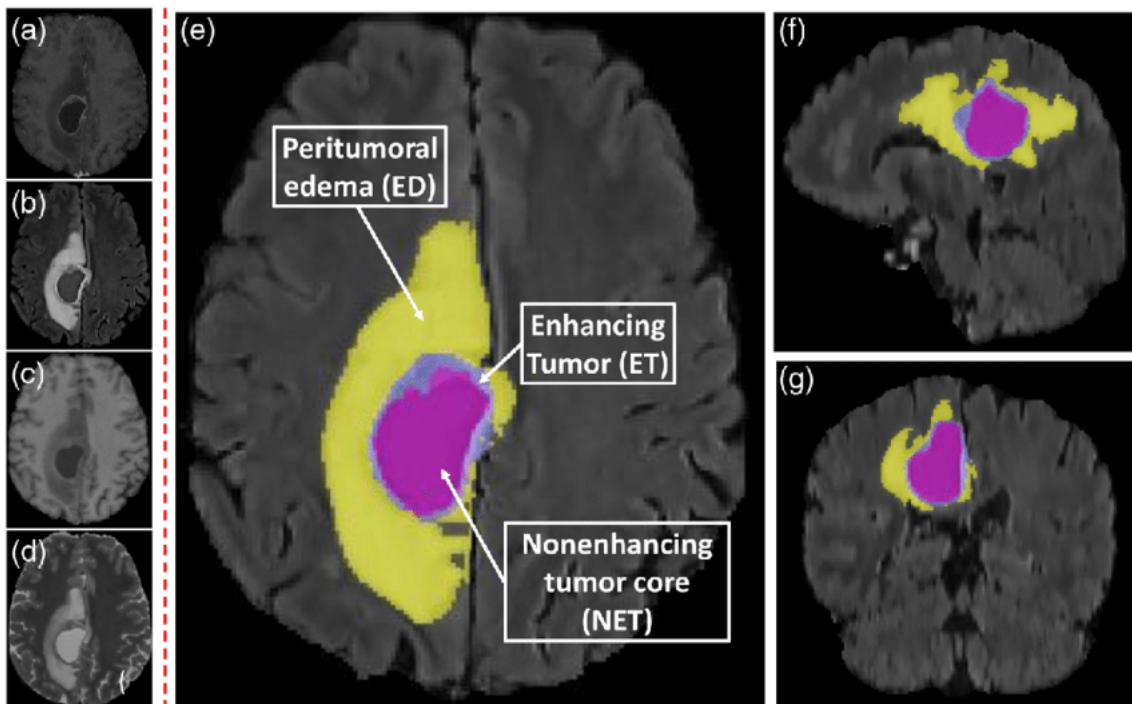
(a)T1 (b) T1-weighted (c) Flair (d) T2 (e) axial view of Segmented Brain Tumor MRI Image (f) sagittal view (g) coronal view
